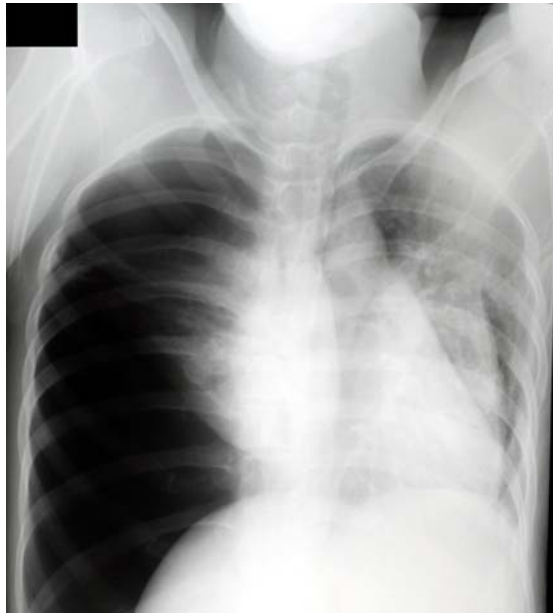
Chest radiograph image shows an almost complete pneumothorax in the right lung.
